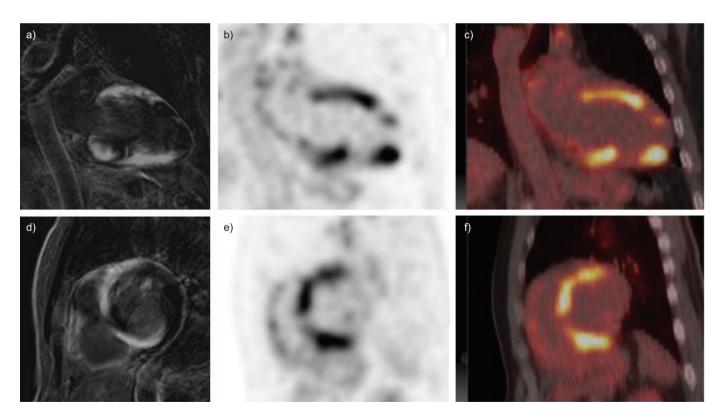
a, d) Magnetic resonance imaging (MRI) and b, c, e, f) ¹⁸F-fluorodeoxyglucose position emission tomography/computed tomography (¹⁸F-FDG PET/CT) of a 49-yr-old male with sarcoidosis and ventricular arrythmias. MRI demonstrated a diffuse hypokinetic left ventricle with an ejection fraction of 35% and enhancement in T2 weighted images in the anterior, inferior and interventricular septal wall. ¹⁸F-FDG PET/CT after a carbohydrate-restricted diet revealed that the majority of these lesions were still active. An implantable cardioverter defibrillator was implanted because of the arrhythmias and immunosuppressive therapy was started given the presence of active inflammation in the myocardium.
